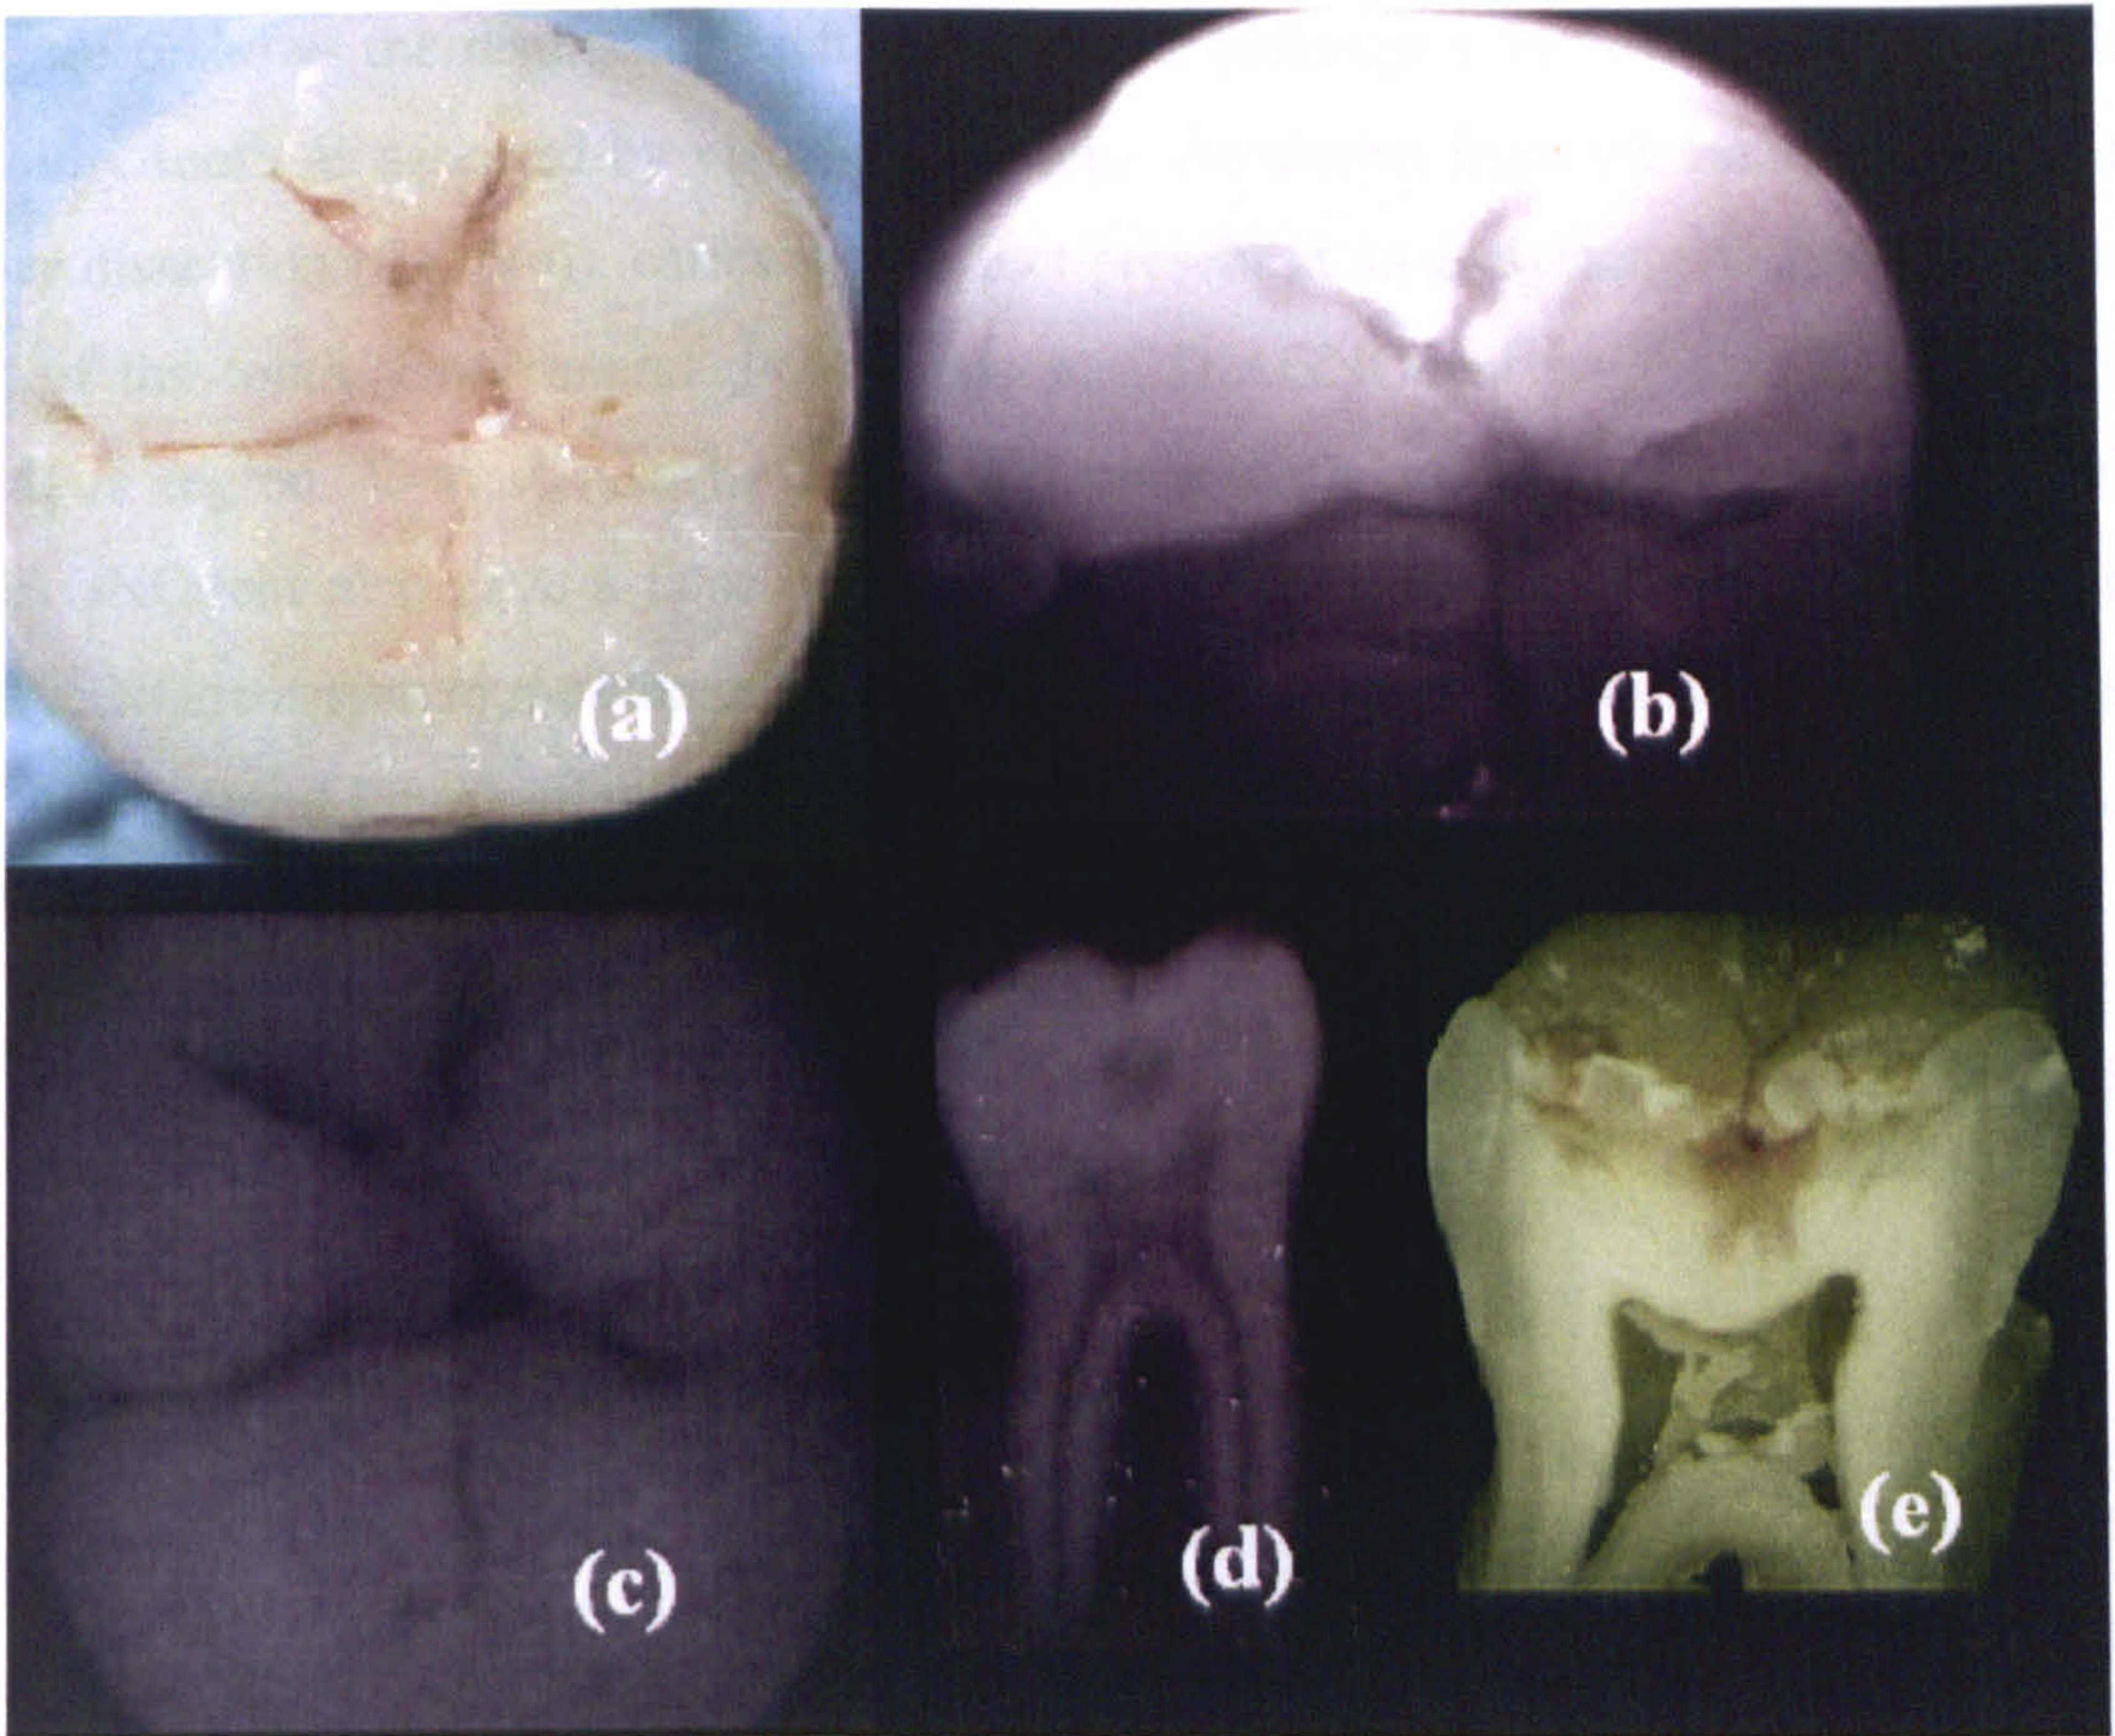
Showing *cavitated I* decay using all techniques (a) Visual Inspection, (b) Lateral Illumination, (c) QLF, (d) Bitewing X-ray photography, (e) Visual Inspection after dissection.
